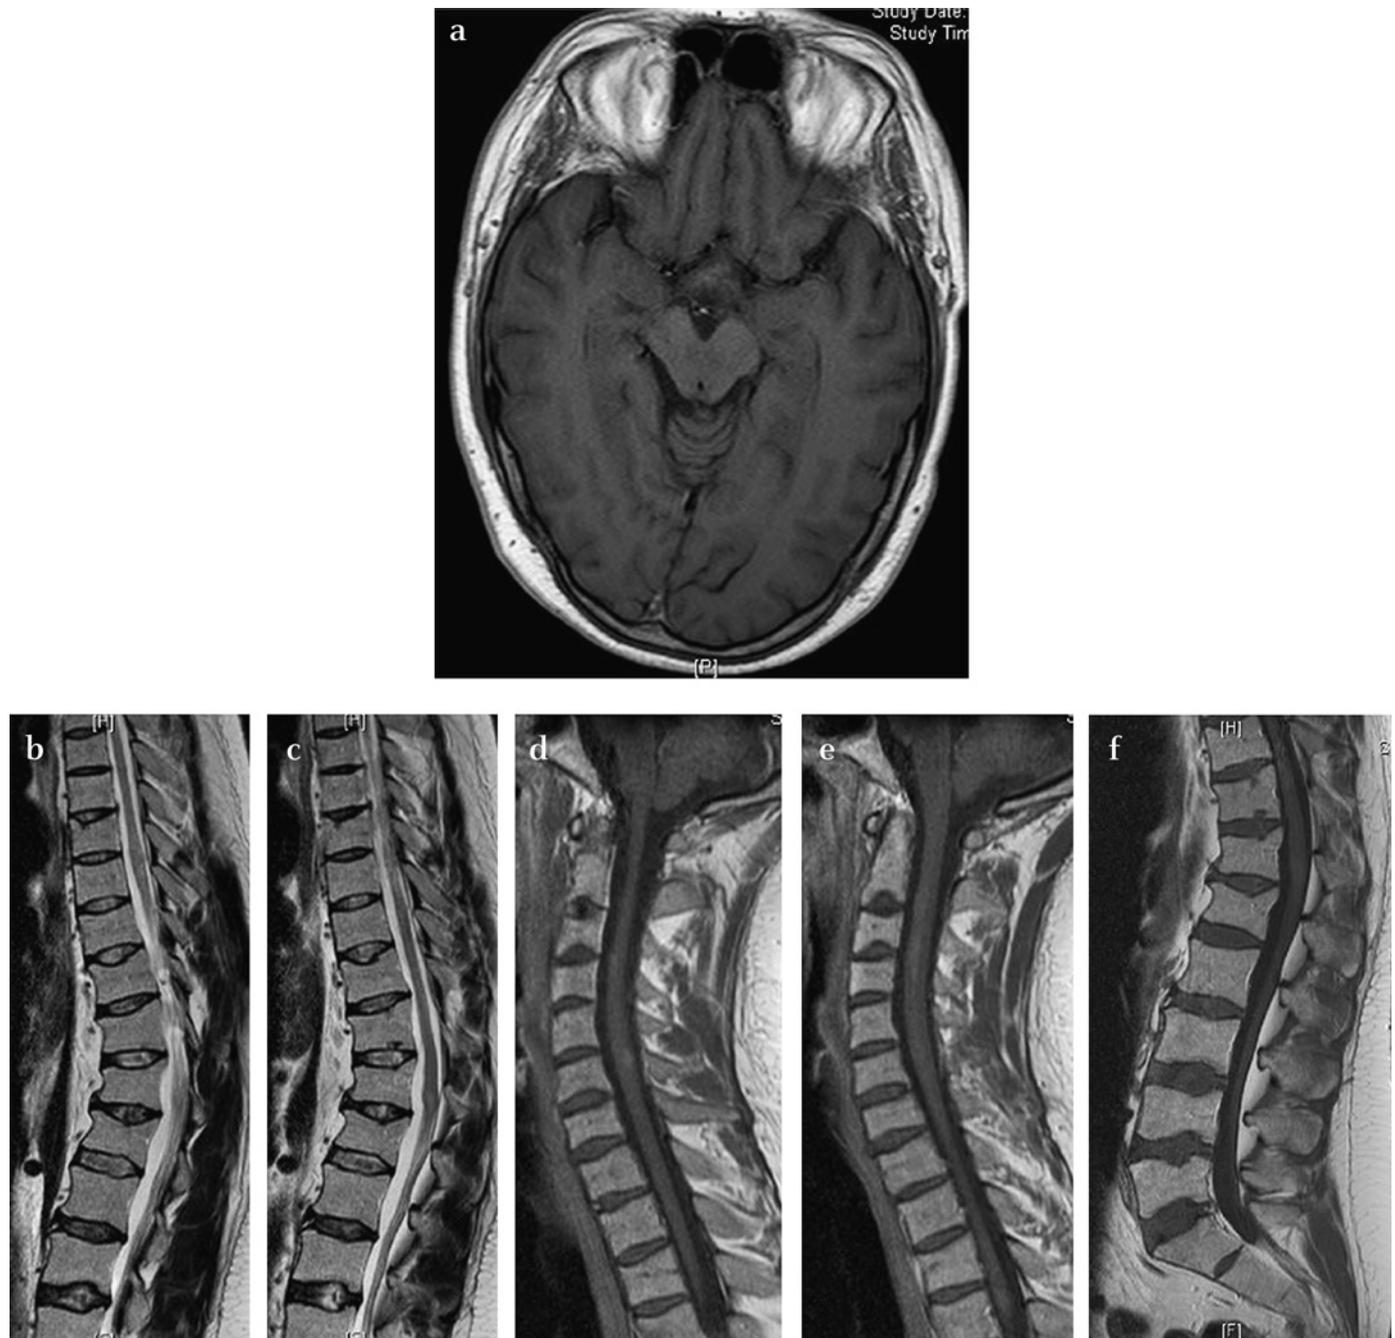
Cranial axial T1 weighted gadolinium enhanced MR image (A) confirms marked improvement following treatment with Infliximab. There is minimal residual meningeal thickening and enhancement at the chiasm. Similarly, spinal MR images (B–F) after Infliximab demonstrate a significant improvement with a marked reduction in cord oedema in the T2 weighted sagittal images of the thoracic spine (B, C) and a reduction in the leptomeningeal thickening, nodularity and enhancement in the T1 weighted gadolinium enhanced sagittal images of the cervical spine (D, E) and conus (F).
